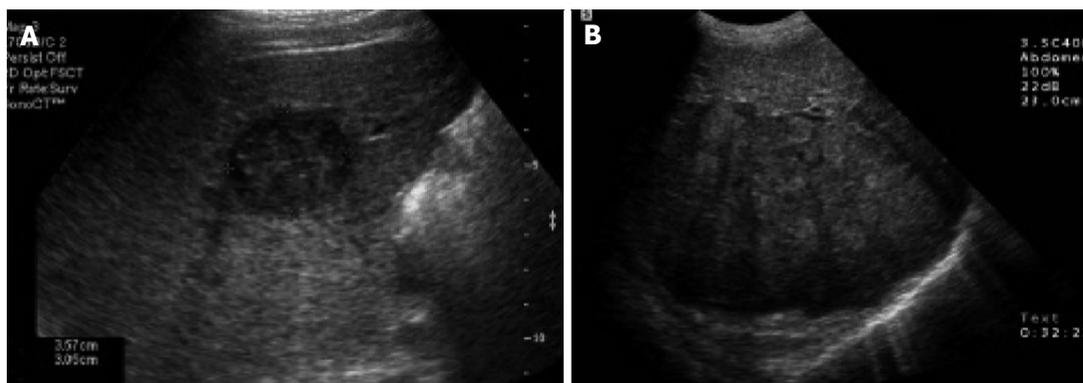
Abdominal ultrasound of the liver. A: Transverse sonogram shows a small, 3 cm, hypoechoic mass in the right lobe of the liver; B: Transverse sonogram shows a heterogeneous large mass in the right lobe of the liver.^[47]
